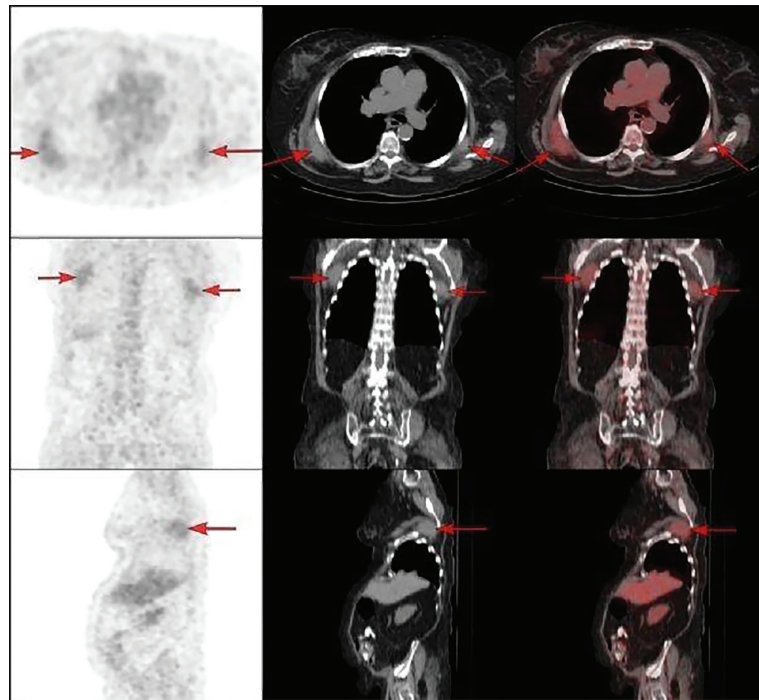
A 67-year-old female patient with a diagnosis of endometrial cancer underwent F-18 FDG PET/CT follow-up, which incidentally revealed findings consistent with elastofibroma dorsi (right SUV_{max} : 2.50- left SUV_{max} : 2.40). The condition manifested as mildly hypermetabolic uptake in soft tissue density within both subscapular regions (red arrows). (From top to bottom; axial, coronal, sagittal and left to right F-18 FDG PET, CT and F-18 FDG PET/CT fusion images are presented).
